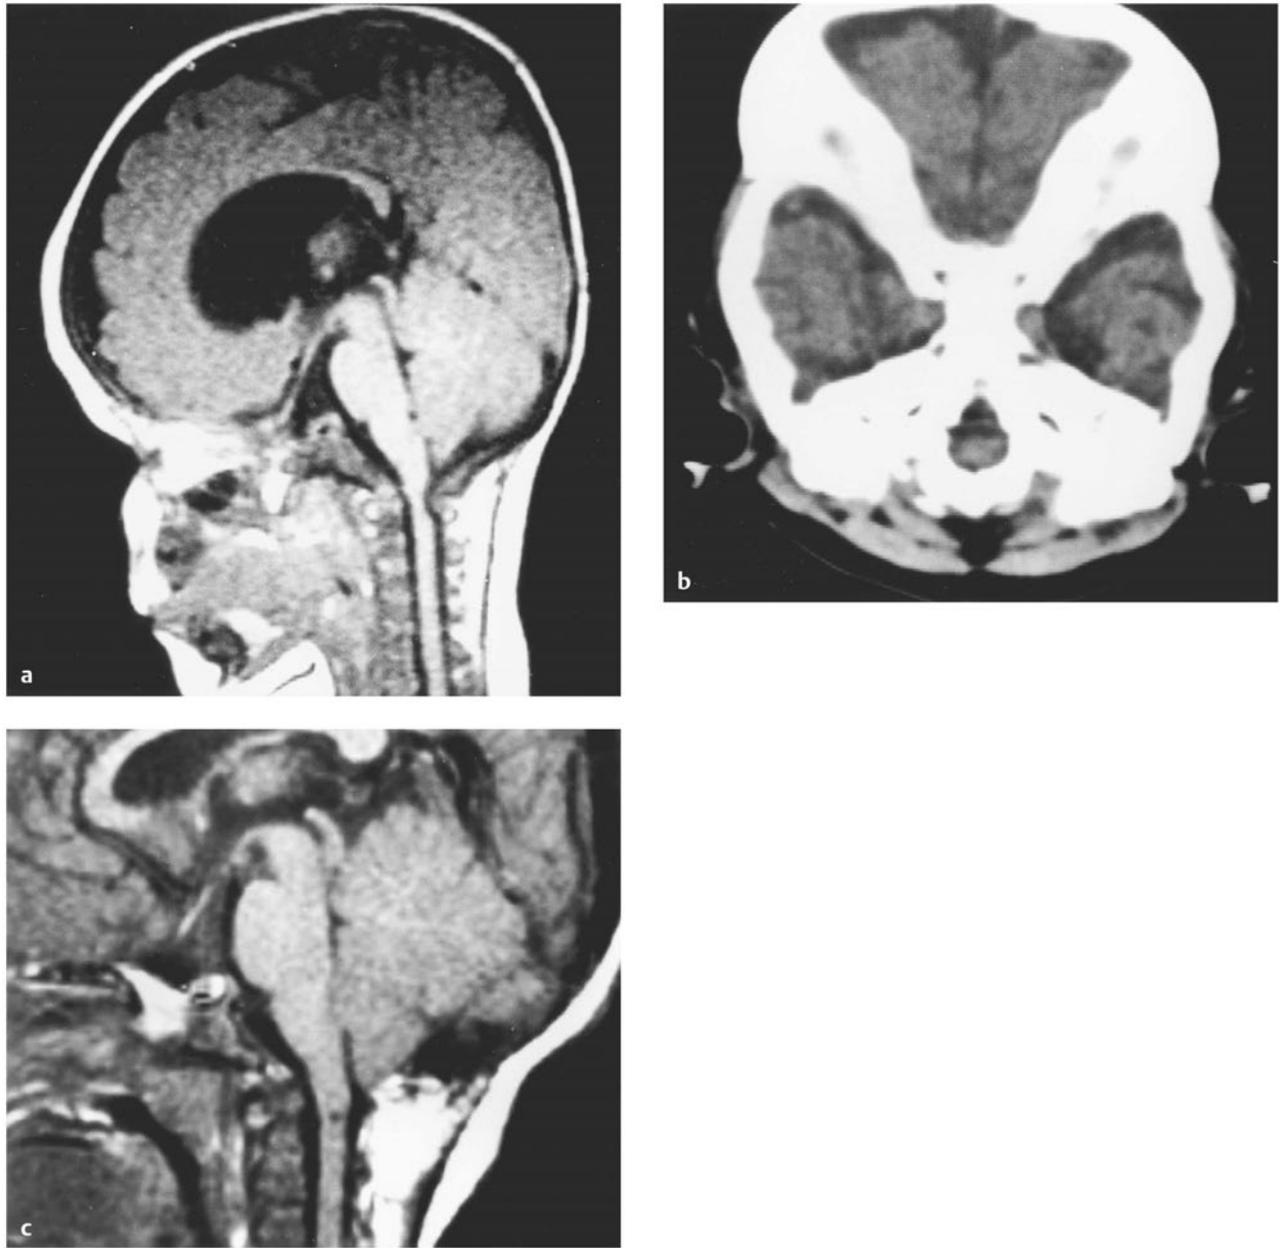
(a) Lateral midsagittal T1-weighted magnetic resonance (MR) imaging of the brain and spinal cord in a 3-year-old child with achondroplasia. Repeated aspiration pneumonia and failure to thrive with weak arms brought her to neurosurgical attention. There is dorsal foramen magnum compression of the cervicomedullary junction. Note the hydrocephalus and the vertical orientation of the brainstem. (b) Axial computed tomographic scan through the plane of the foramen magnum visualizes the constriction in the sagittal as well as the coronal diameter. (c) Postoperative MR imaging in T1 mode following posterior fossa decompression and C1 laminectomy. A duraplasty was made. The decompression is satisfactory. Myelomalacia is seen at the C1 level.
